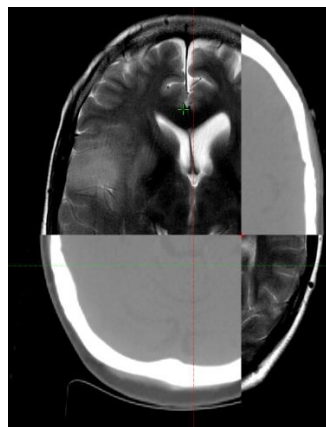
Qualitative checks performed to verify accuracy of rigid image registration between MRI sequences and primary CT dataset using the split-screen tool. Note appearance of bone as black on T2 MRI and white on CT.
